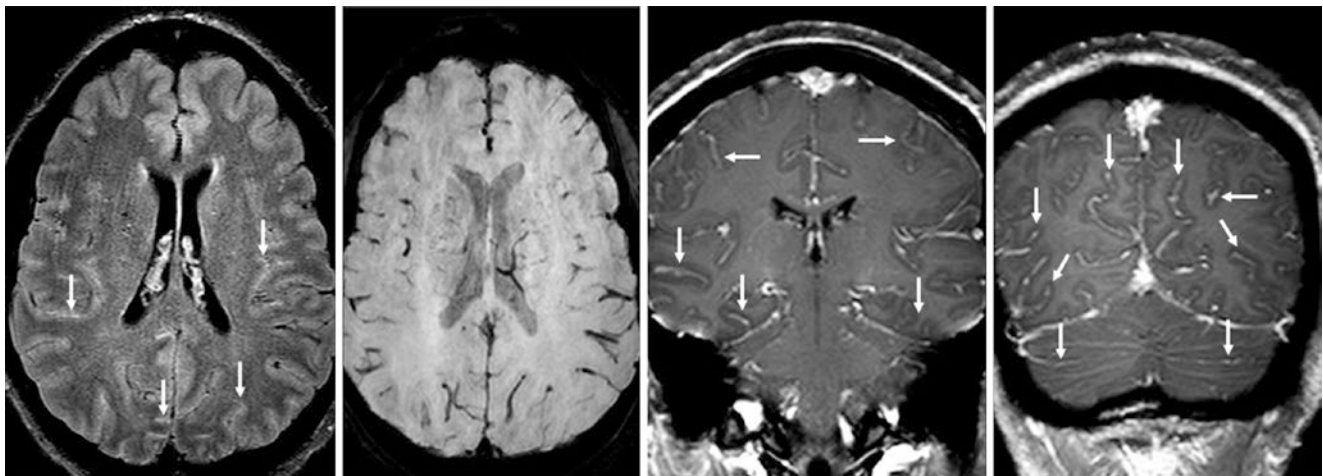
Comparison case of cryptococcal meningitis. A 20-year-old HIV+ female with altered mental status had subtle LMCE (*arrows*) on 3T CE FLAIR (*left*). SWI (*left middle*) also showed that the LMCE
